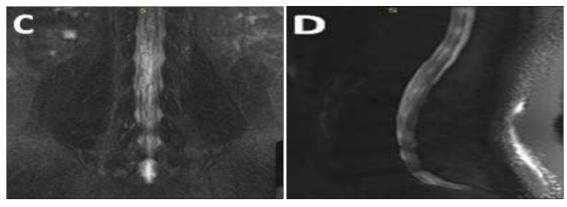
Conventional MRI: axial T₂ (A) and sagittal T₂ (B): abnormal distribution of central nerves within thecal sac (suggesting arachenoiditis), MRN: 3D coronal STIR (C) & sagittal myelogram (D): perineural edema and altered nerve signal intensity at right exit foramina
